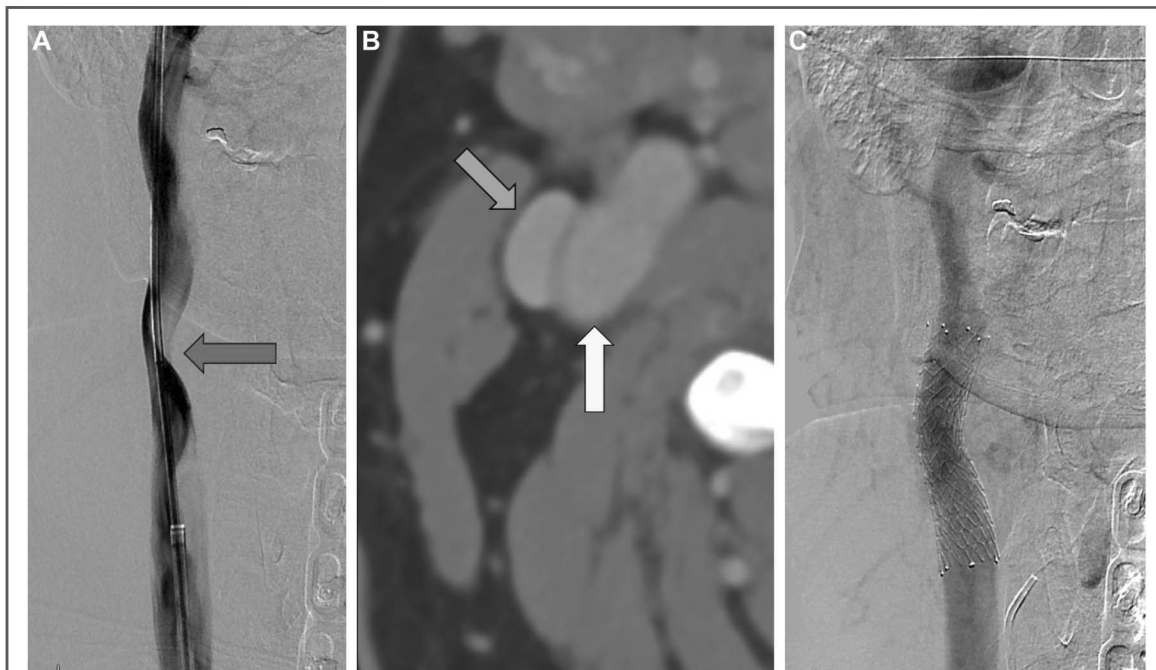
Venography demonstrates severe stenosis of the right IJV at C4–5 with a 4-mm Hg trans-stenosis gradient (A, red arrow). Computed tomography confirmed extramural compression of the IJV (B, blue arrow) between the sternocleidomastoid muscle and the right carotid artery (yellow arrow). C, Stenting was performed with an oversized 12-mm stent without complication, resulting in alleviation of the gradient and significant symptomatic improvement that has persisted. IJV, internal jugular vein.
